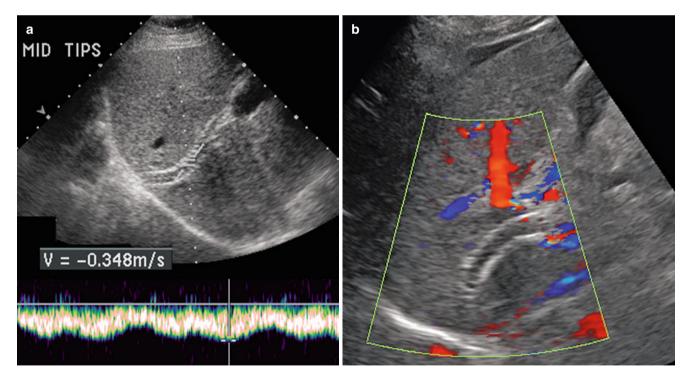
TIPS malfunction and occlusion. (a) Spectral Doppler from mid-TIPS demonstrating slow flow at 35 cm/s. (b) Follow-up color Doppler sonogram demonstrates no flow in the TIPS due to occlusion
